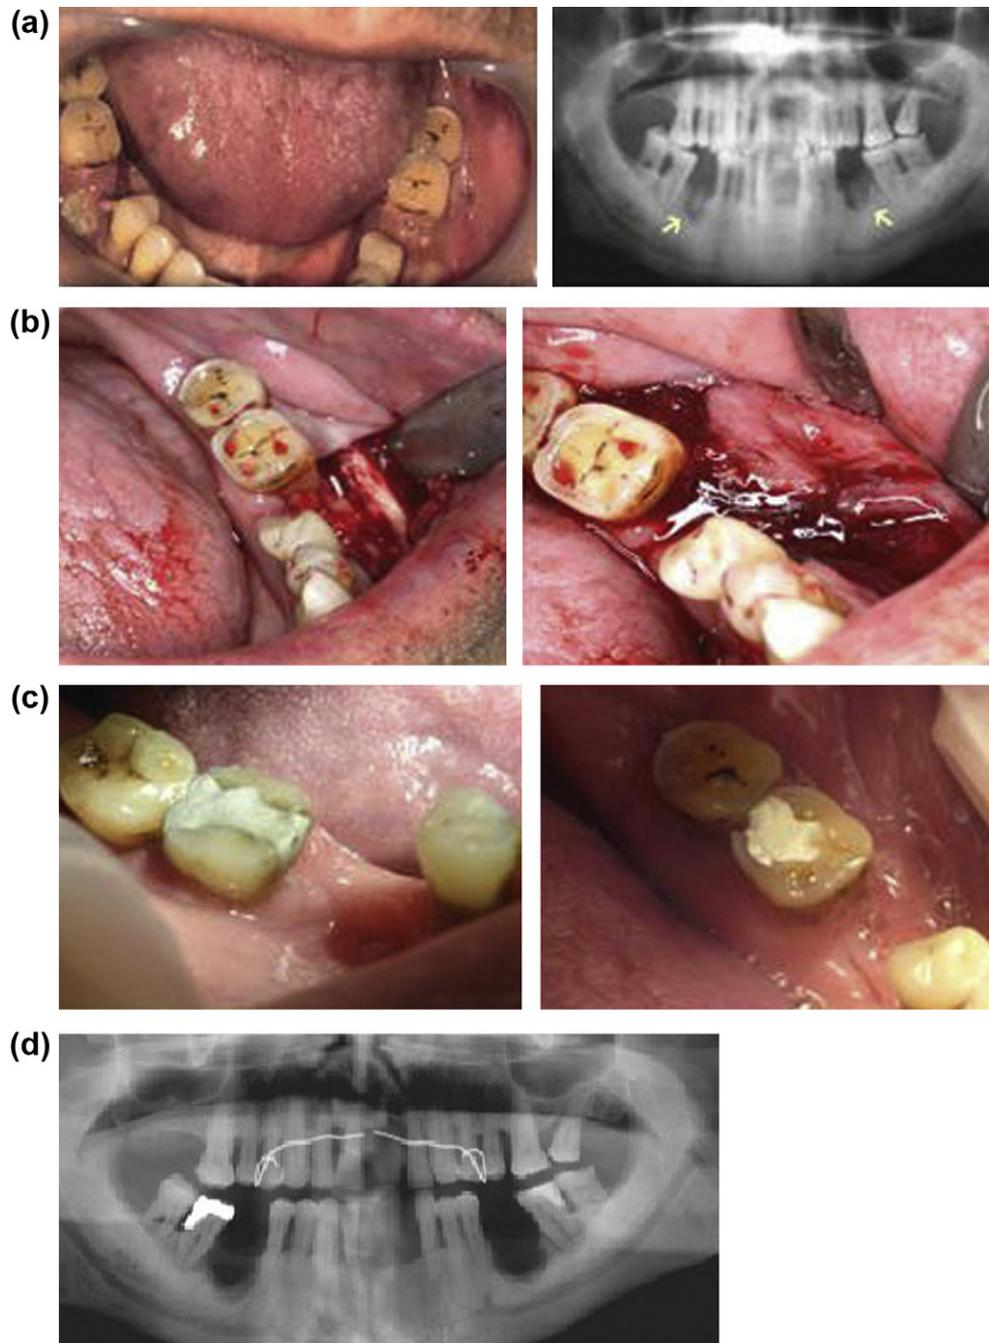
Evolution of Case 5. (a) Suppuration related to prior exodontia of 36 and 46. Panoramic radiograph shows radiolucent areas containing radiopaque areas within. (b) Surgical intervention on the left side and PRP application. (c) Examination after 21 months of follow-up. (d) Panoramic radiograph during the week 4 examination, revealed bone loss surrounding 36 and 46 with sharp margins and no bone sequestration.
